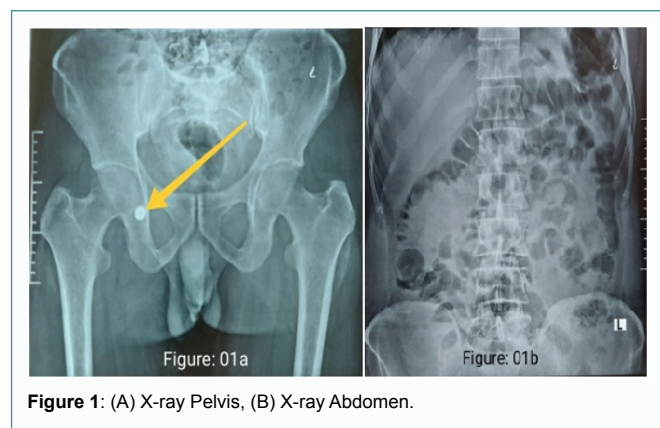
(A) X-ray Pelvis, (B) X-ray Abdomen.
